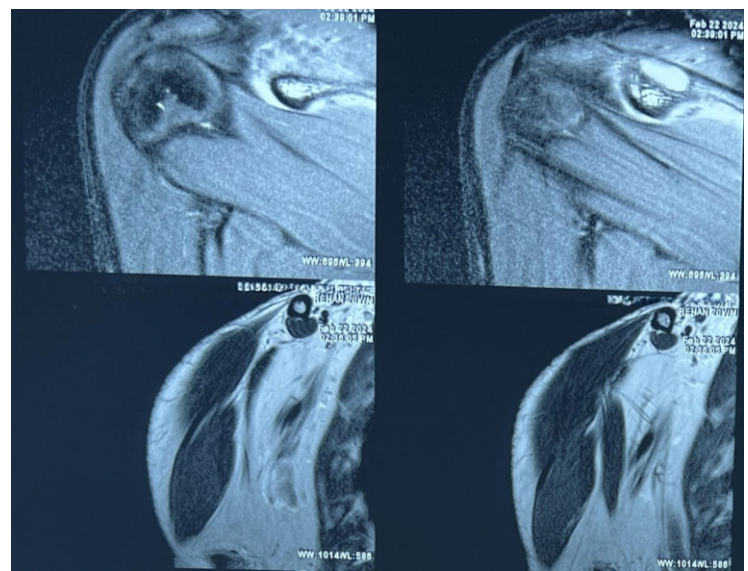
Magnetic resonance imaging of the right shoulder shows an abnormal marrow signal intensity lesion in the lateral aspect of the spine of the right scapula extending into the proximal acromion process associated with intraosseous and extraosseous soft tissue, cortical breach, narrow zone of transition, and diffuse surrounding myocutaneous inflammatory changes.
